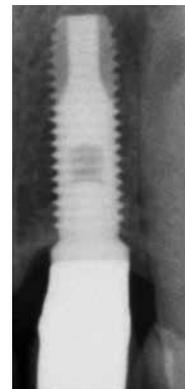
Radiographic condition of implant 22, 5 years after completion of the treatment.
